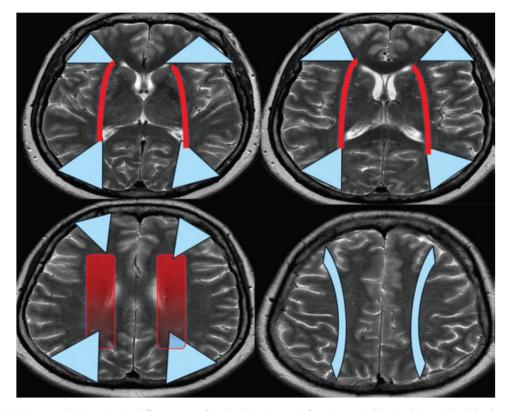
MRI T2W images axial view showing different types of cerebral border zone infarct. (External (blue) and internal (red) border zone infarct).
